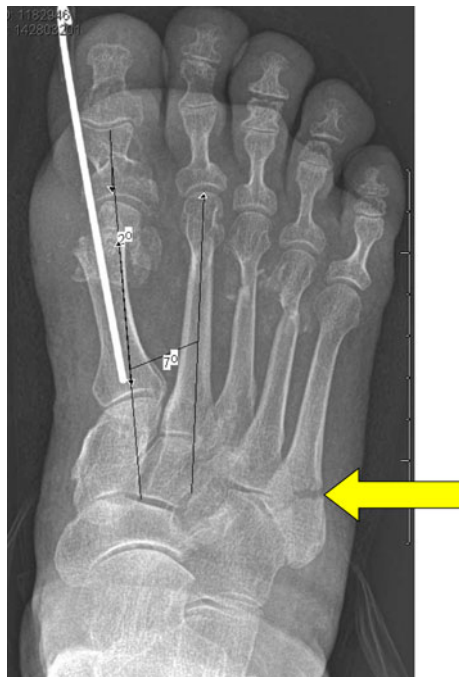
Control radiograph on postoperative day six shows a styloid fracture of the fifth metatarsal bone (arrow)
